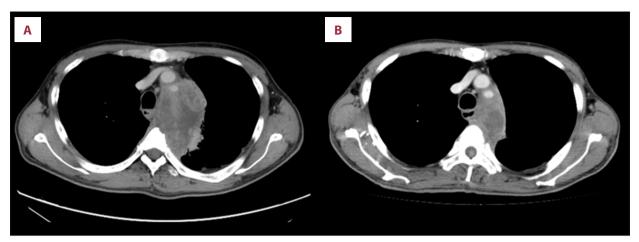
CT images. Lung adenocarcinoma is present in the mediastinum from the left upper lobe before nivolumab treatment in May 201X (A). Hospitalization for FN on day 32 after administration of the first dose with nivolumab. The tumor is significantly reduced with no appreciable source of infection on CT (B).
